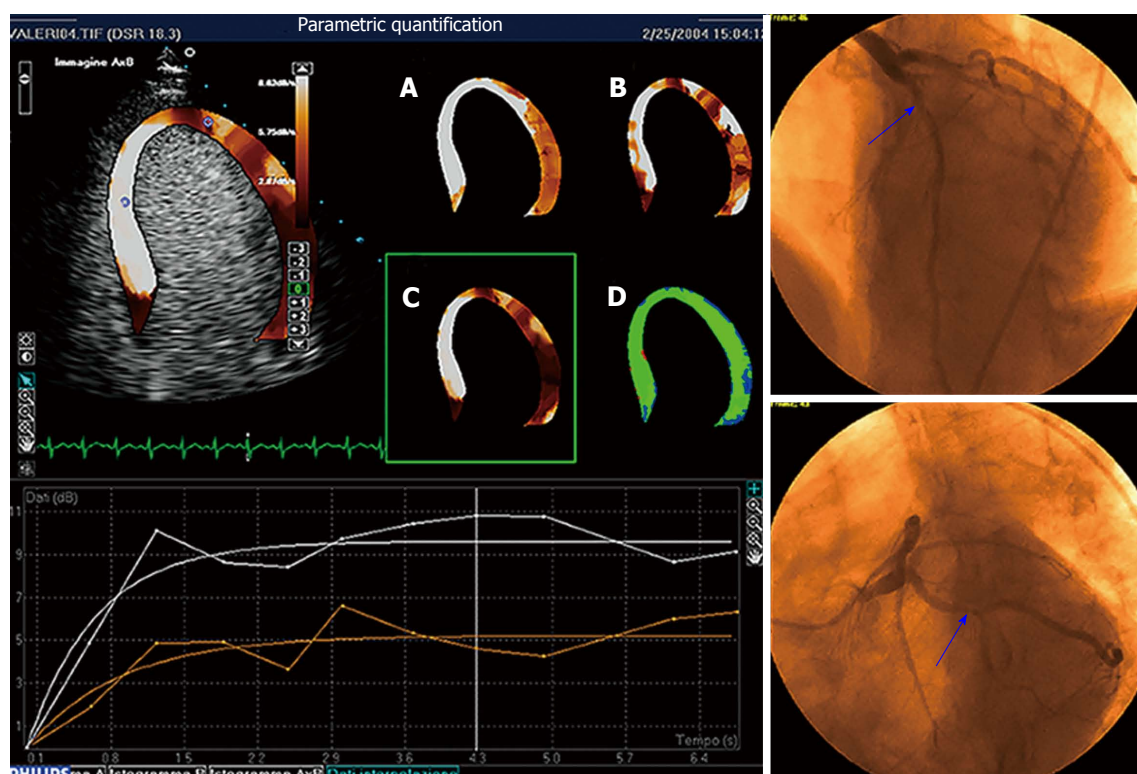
Parametric quantification of myocardial perfusion. Critical stenosis of the circumflex artery is present at coronary angiography (right panels). Parametric images of peak dipyridamole stress echo reported in panels A through D represent, respectively, the plateau value A of the contrast replenishment curve, the slope β of the replenishment curve, the $A \times \beta$ value, and the goodness of fitting. The $A \times \beta$ value parametric imaging is also displayed superimposed onto the apical four-chamber view in the top left panel. Replenishment time-course curves (sampling and interpolation) relative to the septum (white curves) and the apico-lateral wall (red curves) are reported in the graph at the bottom. Flow is reduced in the territory perfused by circumflex artery.
